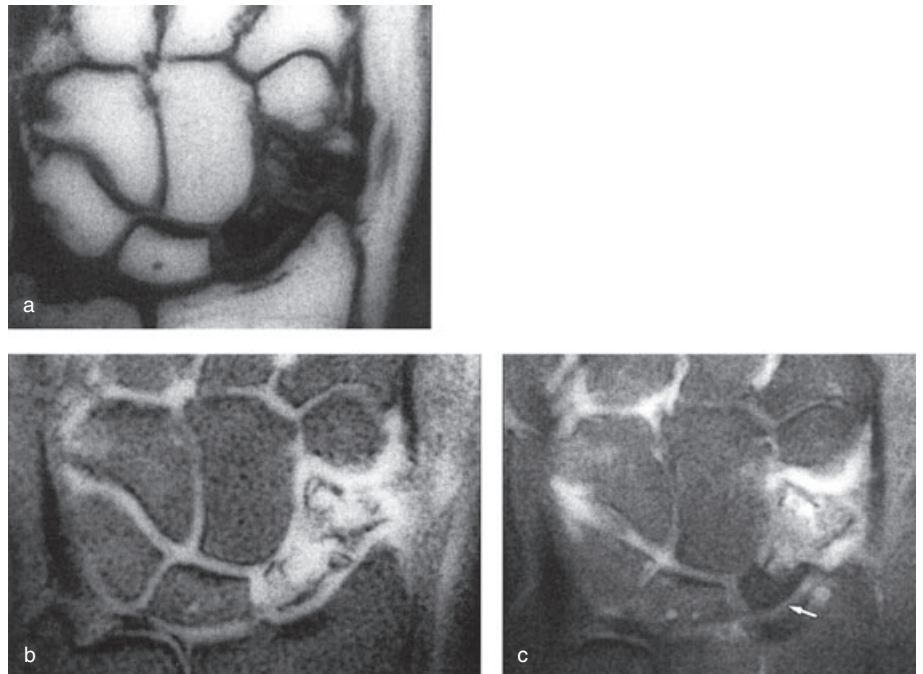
Avascular necrosis of the scaphoid. MRI showing coronal T1-weighted image (a) with low signal intensity of the proximal fragment. T2-weighted, coronal fat-suppressed image (b) showing heterogeneous signal intensity of the proximal fragment. Coronal gadolinium-enhanced fat-suppressed T1-weighted image (c) showing a lack of enhancement (arrow) of the proximal pole of the scaphoid. (With permission from Lippincott Williams & Wilkins. Cerezal L, Abascal F, Canga A. Usefulness of gadolinium enhanced MR imaging in the evaluation of the vascularity of scaphoid non-unions. *American J. Roentology.* 2000; 174: 141–9).
